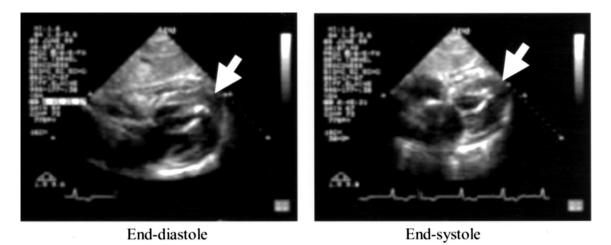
Echocardiographic images of the left ventricle from the subcostal view. Image quality is suboptimal, a common limitation of echocardiography, particularly for evaluation of the apical left ventricle. Focal apical hypertrophy with regional hypokinesis can be identified (arrows).
